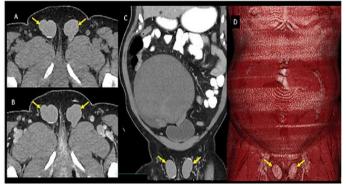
computer tomography (A) non contrast axial section, (B and C) post contrast, porto-venous, axial and coronal (D) 3D color coded coronal shows Bilateral implanted testis with homogenous CT density about 70 Hounsfield in pre and post contrast (yellow arrows).
